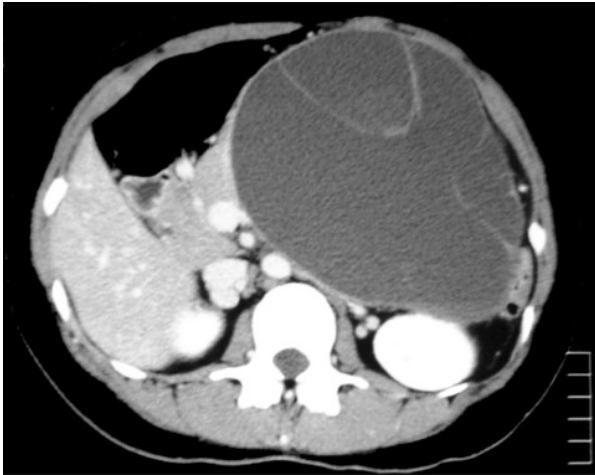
An abdominal CT showing a large (15 cm diameter) cystic tumor of the pancreatic cyst consistent with mucinous cyst adenocarcinoma.
